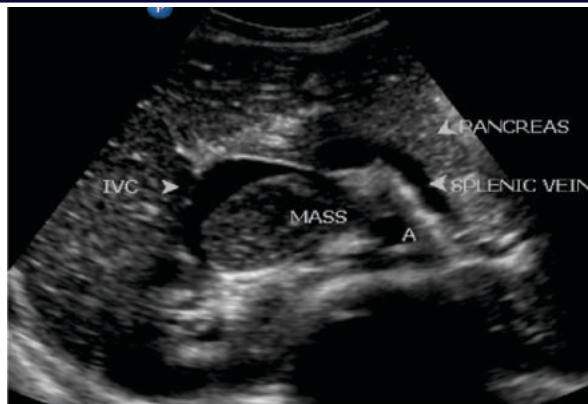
Hodgkin's lymphoma. A – Aorta and IVC – Inferior Venacava. A 10 year old male presented with severe anaemia and ultrasound of the abdomen revealed retroperitoneal lymphadenopathy. The image shows enlarged retroperitoneal lymph node causing mild compression of the IVC. All the lymph nodes were homogeneous and none of them showed necrosis or calcification.
